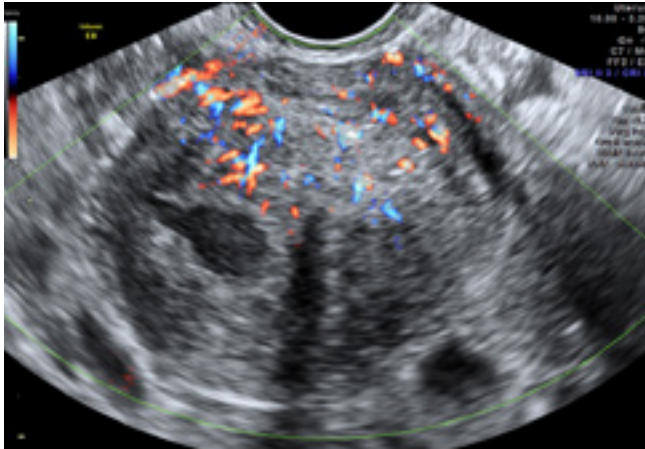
Intramural myoma – uterine tumor with mixed echogenicity, rich vascularization in color Doppler
